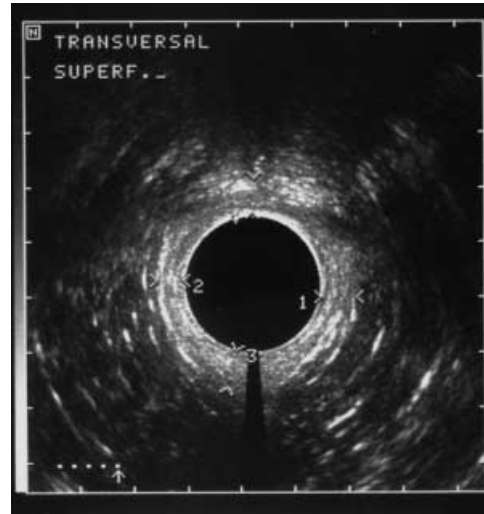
Endosonographic image of the external anal sphincter (pars subcutanea) which appears hyperechoic. Thickness is measured in all quadrants resulting in a mean value of 6.2 mm in this case
